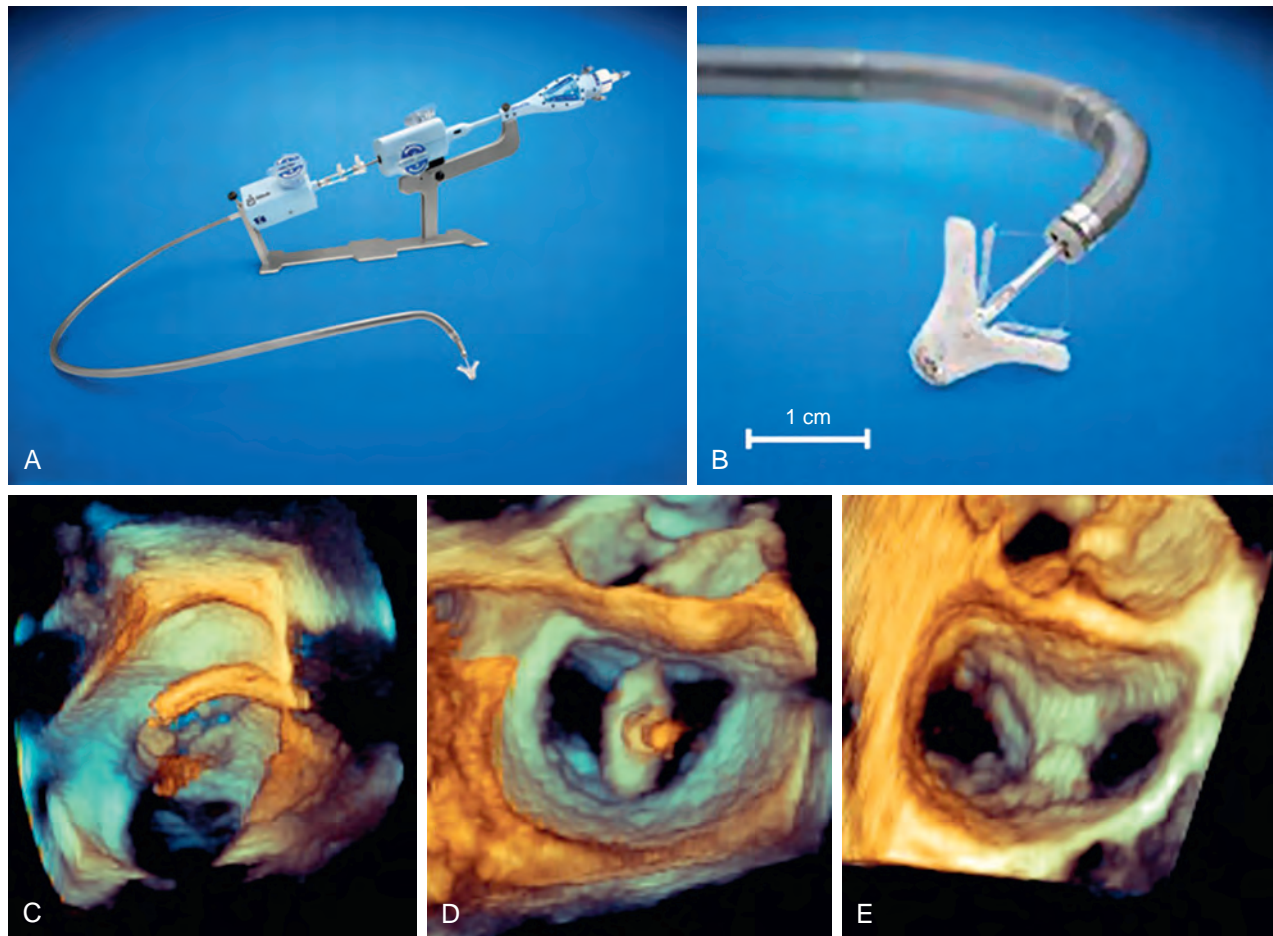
(A) MitraClip delivery system. (B) Enlarged view of MitraClip delivery system with the clip inserted. (C) Three-dimensional transesophageal echocardiographic image shows the delivery system crossing the interatrial septum. (D) MitraClip orientation is perpendicular to the valve coaptation plane. (E) Mitral valve is shown after MitraClip placement at the anterior leaflet (A) and the posterior leaflet (P) interface with the generation of a double-orifice valve. (Reproduced with permission from Rogers JH, Franzen O. Percutaneous edge-to-edge MitraClip therapy in the management of mitral regurgitation. *Eur Heart J*. 2011;32:2350–2357.)
